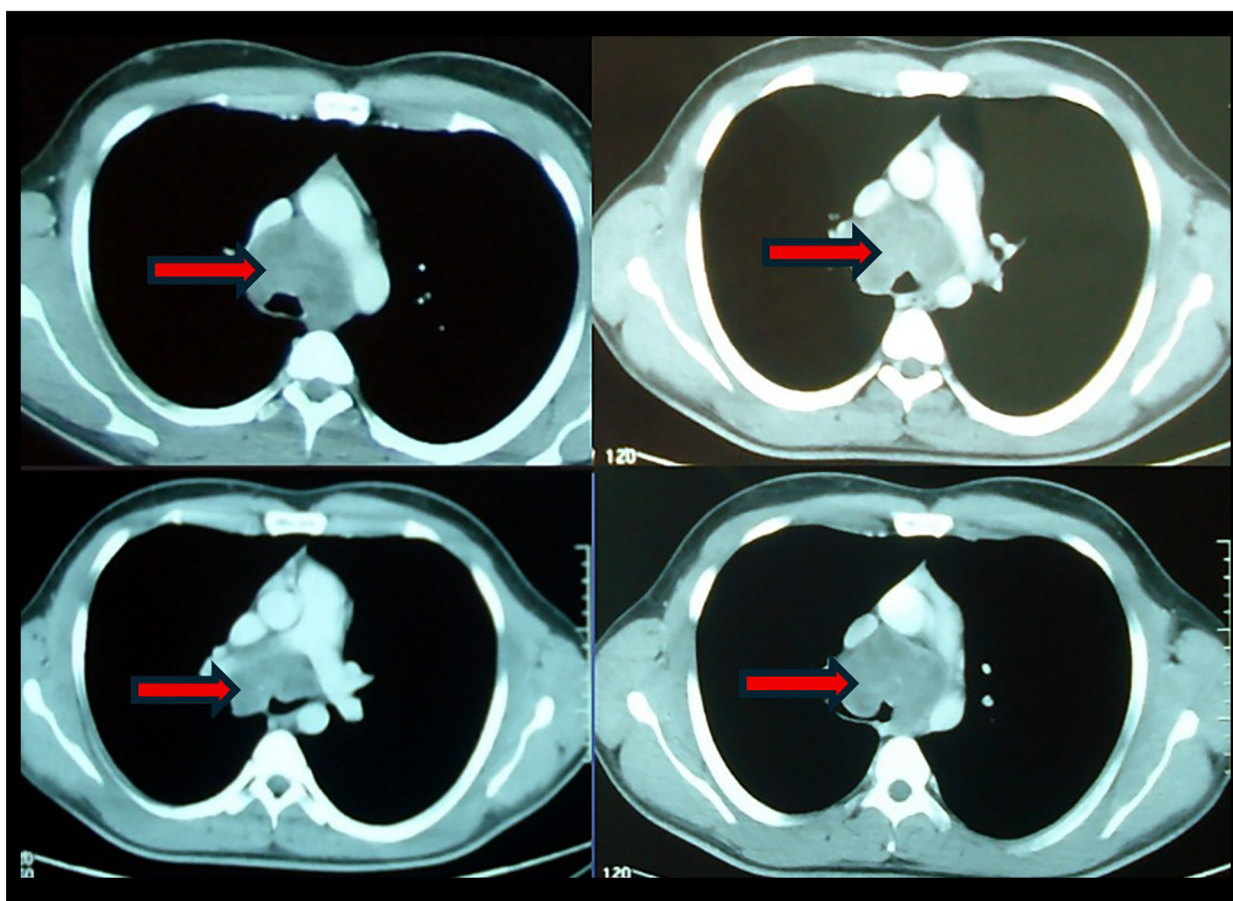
Chest computed tomography images at consecutive levels showing a large lobulated tumor mass causing narrowing of the distal tracheal lumen and the orifices of both mainstem bronchi. Arrows indicate these findings.
